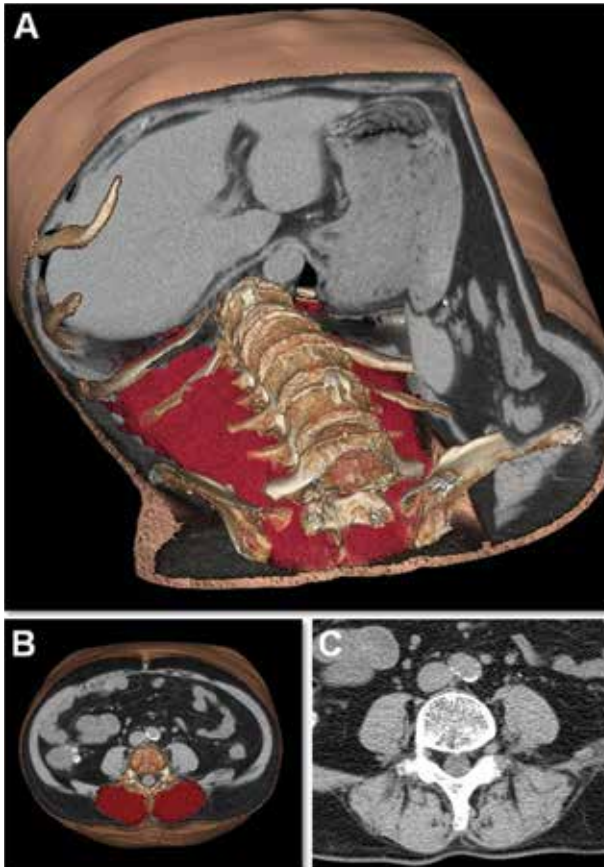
Image of the lumbar muscle and surrounding tissues (*red*). A Computed tomography (CT) images of the muscles behind the vertebral bodies that are covered with the same fascia, B, C intramuscular adipose tissue content (IMAC) values of muscle according to the CT findings at the umbilical level that were used to quantify visceral fat accumulation [17, 18].
